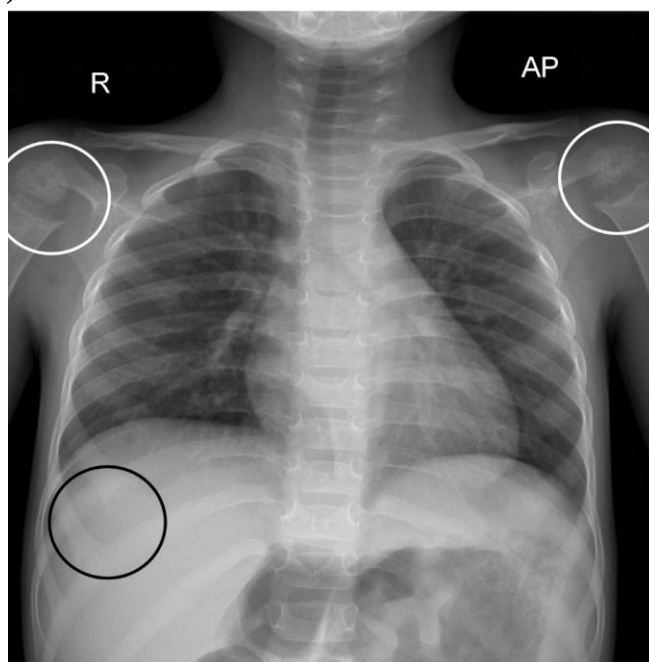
The patient's chest X-ray image shows widening of the anterior rib ends at the costochondral junctions (black circle), and cupping, fraying, and splaying on both sides of the proximal humerus (white circle).
